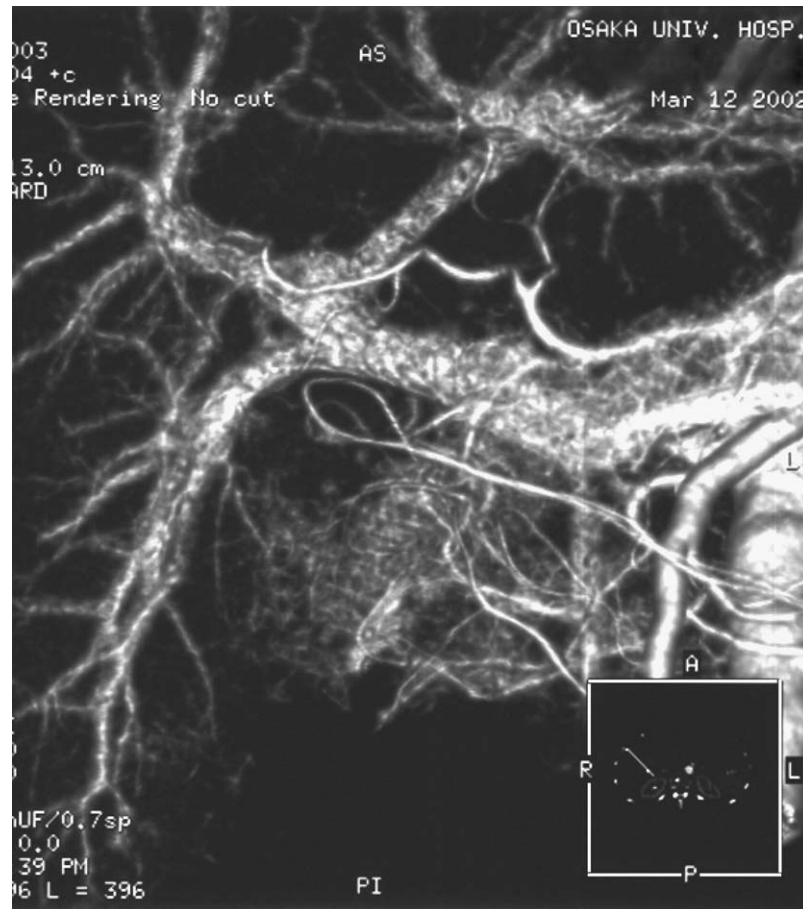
Three-dimensional image from a multidetector-row CT scan. The right posterior hepatic artery passes behind the main portal vein, while the right anterior hepatic artery passes in front of the main portal vein. The right posterior portal vein branched off from the main portal vein and then divided into the right anterior portal vein and the left portal vein.
